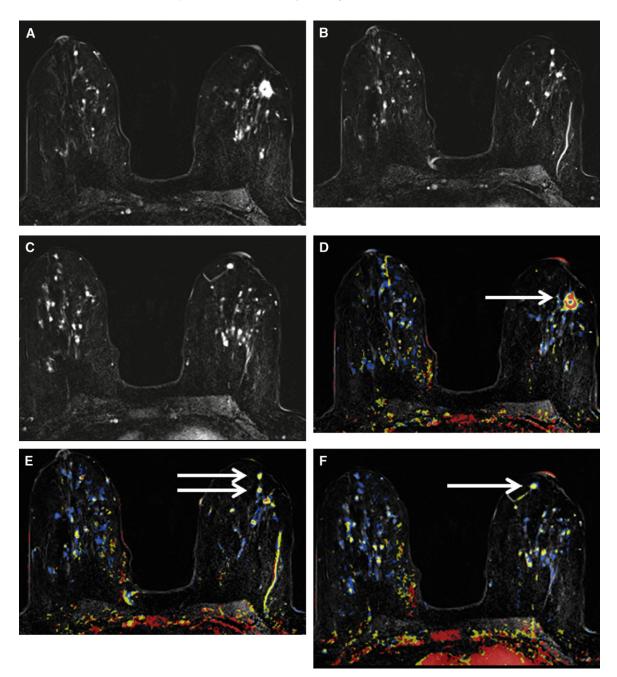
A 52-year-old patient with left invasive ductal cancer and preoperative staging breast magnetic resonance imaging, where computer-aided detection (CAD) permits a quick visual map of lesions, which warrants further workup. (A) Axial T1 2-minute enhanced subtracted image, demonstrating a spiculated enhancing lesion in the left breast at 3 o'clock, which corresponds to the known cancer. (B, C) Axial slices in the same sequence, showing multiple enhancing lesions in both breasts as well as several adjacent to the biopsy proven cancer, difficult to assess on a per lesion basis. (D) Axial enhanced image with CAD software, showing the rim enhancing cancer, which is red with CAD, in keeping with the most suspicious enhancement curve of cancer. The other enhancing lesions in both breasts are blue, in keeping with benign enhancing foci. (E) CAD image of 2 adjacent enhancing lesions that are yellow, in keeping with plateau (type II) curves, which merit further evaluation with second-look ultrasound (US). (F) A third CAD image, demonstrating another yellow lesion at 9 o'clock in the retroareolar location, is concerning for multicentric disease. Second-look US and biopsy of all 3 lesions were diagnostic for benign papilloma and fibroadenomas, which allows breast conservation surgery. This figure is available in colour online at http://carjonline.org/.
